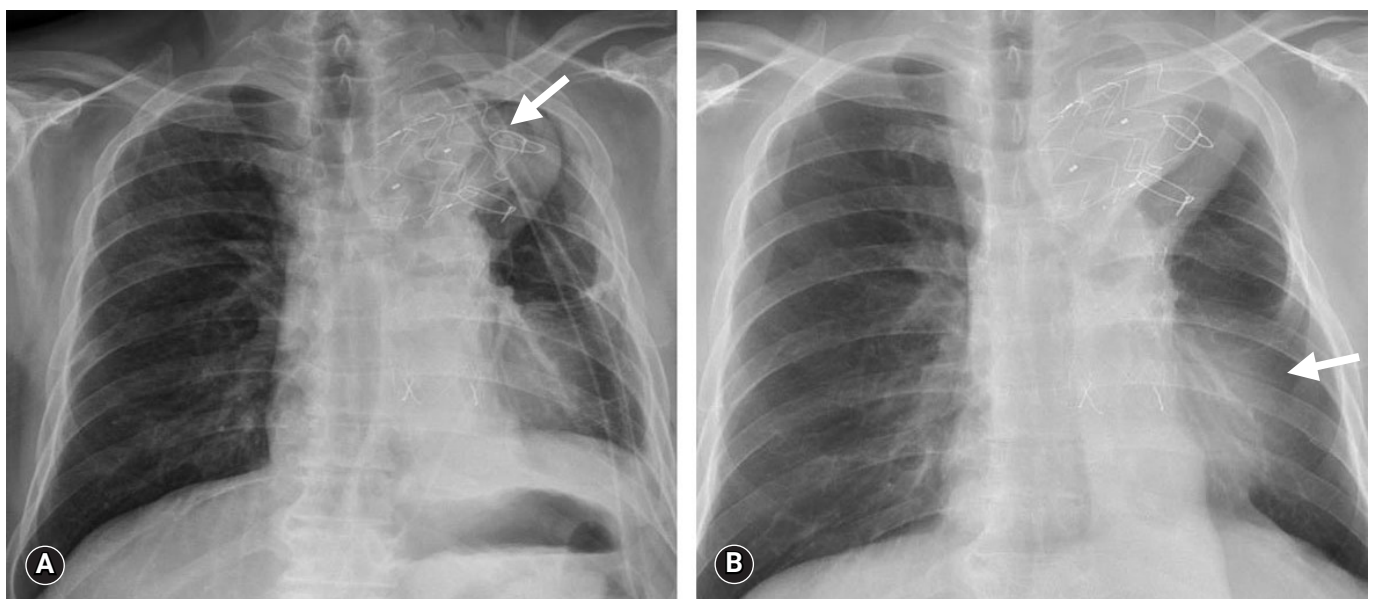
Postoperative chest radiograph findings of case 2. (A) Postoperative chest radiograph shows remnant stent-graft (arrow). (B) Postoperative chest radiograph (followed-up after 4 years) shows the absence of lung lesion (arrow).
